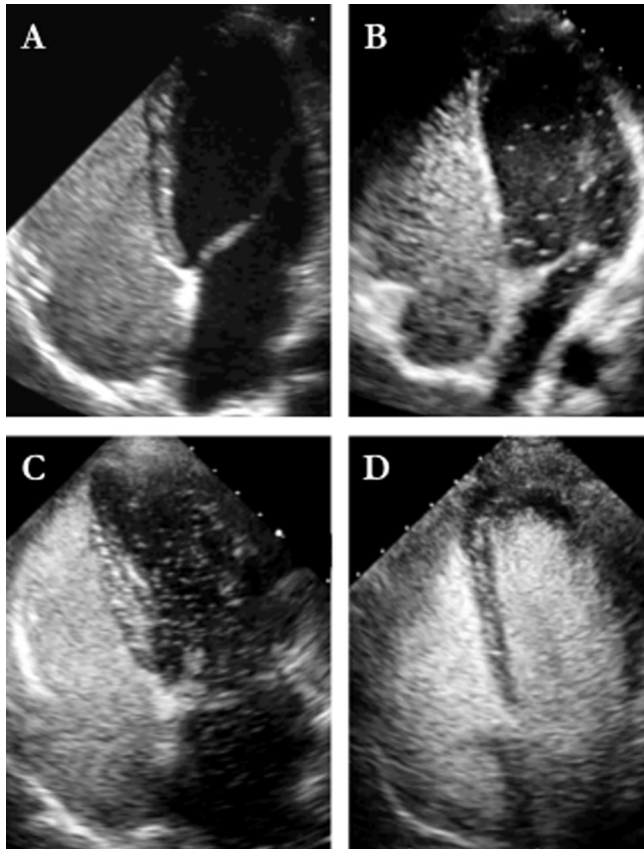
Different pulmonary shunt grades on saline TTCE. Apical four-chamber view, using saline TTCE. (A) No shunt; (B) grade 1; (C) grade 2; (D) grade 3. Adapted from Velthuis *et al.*²⁰ and reproduced with permission of the European Respiratory Society. TTCE, Transthoracic contrast echocardiography.
